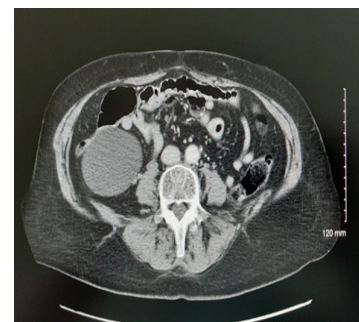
Axial view of CT showing mesenteric cyst.
